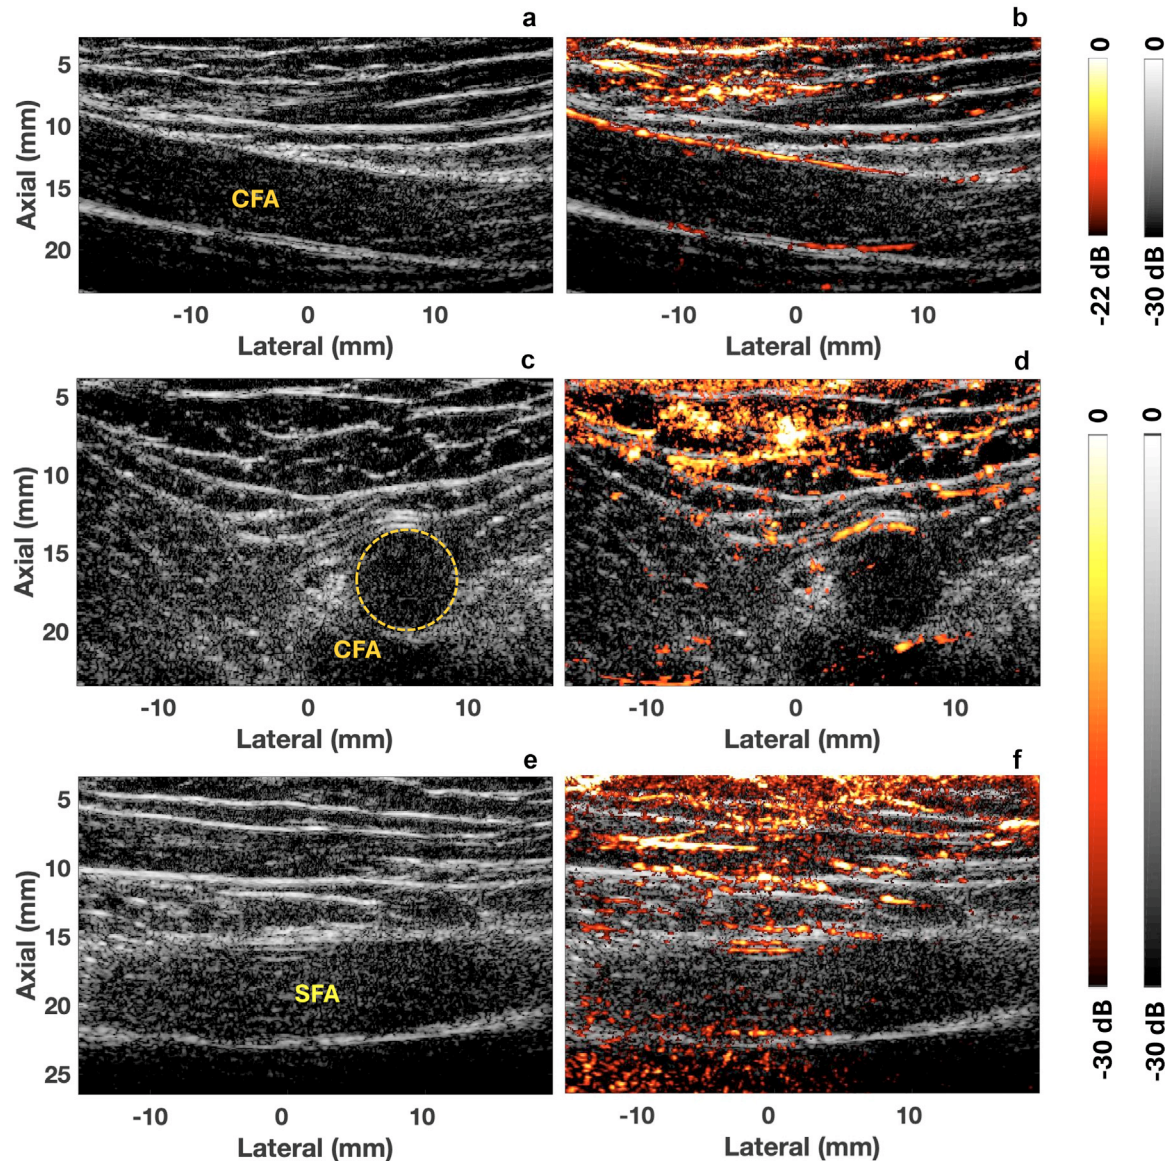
Femoral artery imaging. (a) Longitudinal ultrasound (US) image of the common femoral artery (CFA) and (b) corresponding overlaid photoacoustic image. Cross-section of the CFA (c) US image and (d) overlaid PA image. (e) Longitudinal US image of the superficial femoral artery (SFA) and (f) overlaid photoacoustic image.
